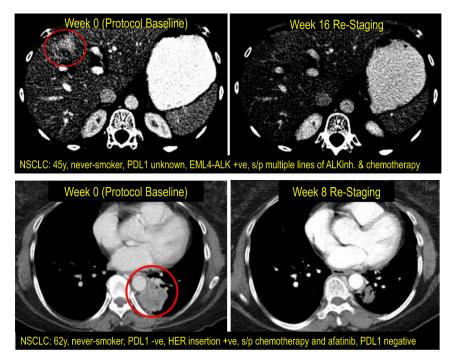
CT Images of Lung Cancer Patients Before and After DAC-THU/Nivolumab Therapy.
